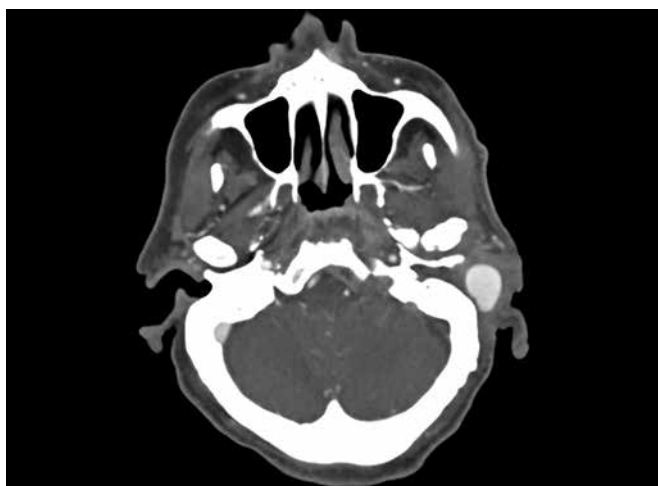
Computed tomography angiogram showing saccular aneurysm in the left external auditory canal
